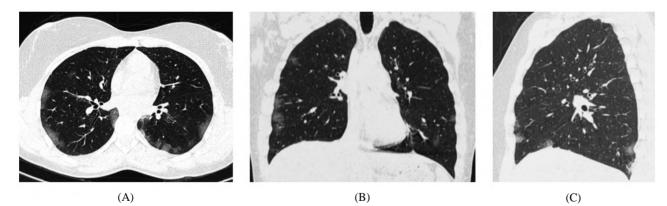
29 years old female patient confirmed positive for COVID 19. (A): Axial CT chest cuts showed sub-pleural areas of ground glassing. (B&C): Coronal and sagittal cuts confirmed multi-segmental involvement of both lung parenchyma with lower lobes predominance.
